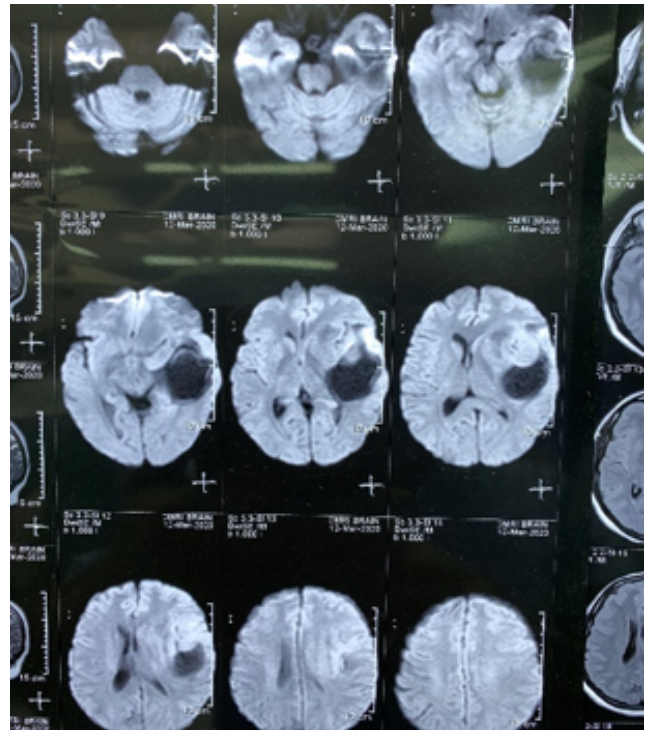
MRI T1weighted image
